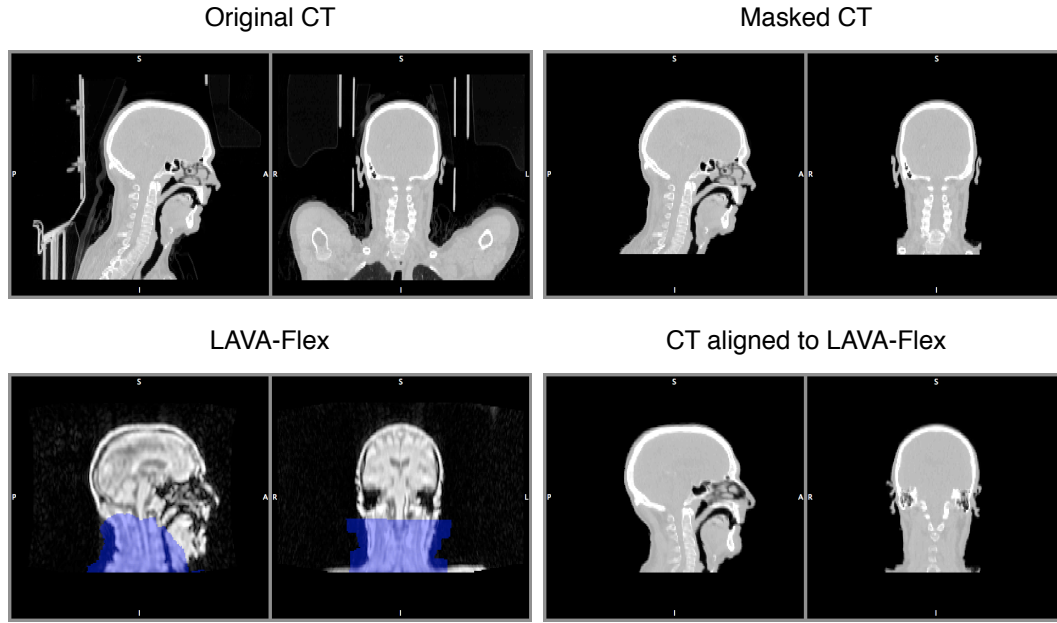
LAVA-Flex/CT database building. The original CT image is masked to remove the bed and arms and facilitate the affine alignment to the LAVA-Flex image. The CT is non-rigidly aligned to the MR image in the neck area (blue) to compensate for changes in position between the PET/CT and PET/MR acquisitions.
